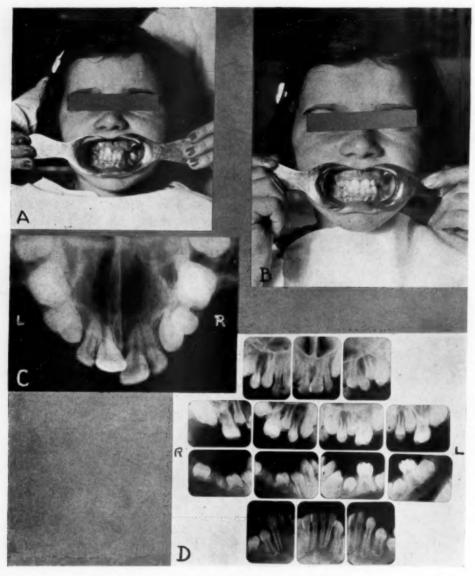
A, Occlusion before orthodontic treatment. B, Occlusion after orthodontic treatment. C, Occlusal x-ray view showing large bony cleft of hard and soft palates involving both sides of septum. D, Full mouth x-ray series of teeth before treatment showing effect of early extractions.
